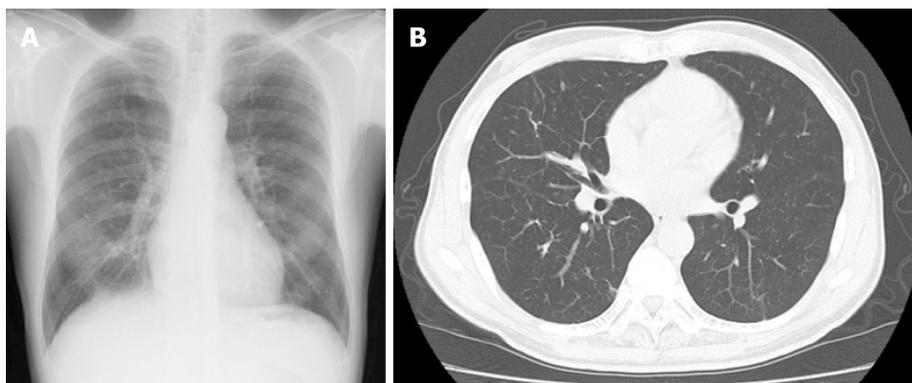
Radiological findings at 6 mo after the patient quit smoking. A: Chest X-ray; B: Computed tomography scan.
